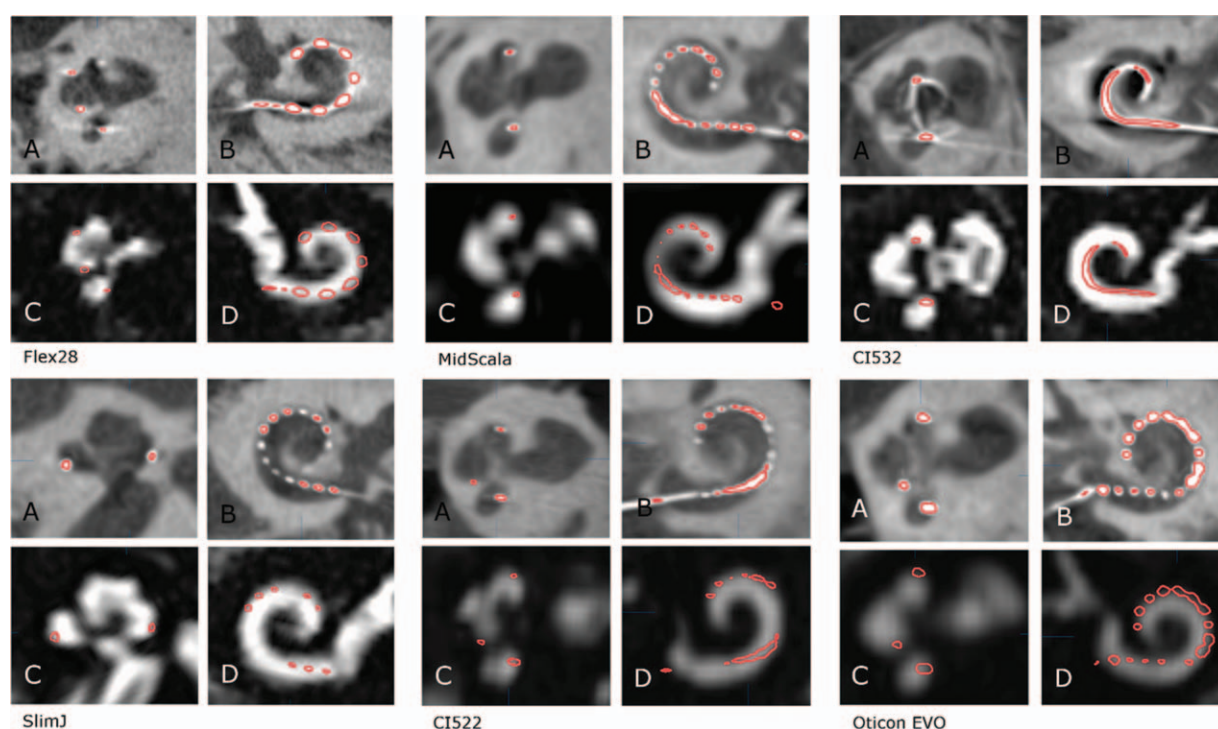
The typical characteristics of each array on CBCT (A–B) and the HU segmented reconstruction (*red line*) on both CBCT and MRI (C–D). Med-EI Flex28: Some artefact. Due to the extensive length of the array, the image fusion helps with apical evaluation, and in basal evaluation in some cases. Advanced Bionics, MidScala: Mostly symmetrical, round artefacts, which do not hinder the location assessment with CBCT. One case with many artefacts. Cochlear CI532: Many artefacts with bone-blurring halos, rays and arches. There is a mostly continuous artefact along the linear length. Image fusion helps considerably. Advanced Bionics SlimJ: Mostly round and symmetrical artefacts, some ray halos and tails. Image fusion helps in apical evaluation in some cases. Cochlear CI522: Symmetrical round artefacts, some lining up. Image fusion helps in some cases, mostly apically. Oticon EVO: Round moderate size artefacts that line up to some extent. Because of the deep insertion length, image fusion helps not only with the apical assessment but also with the basal evaluation. CBCT indicates cone-beam computed tomography; HU, Hounsfield unit; MRI, magnetic resonance imaging.
